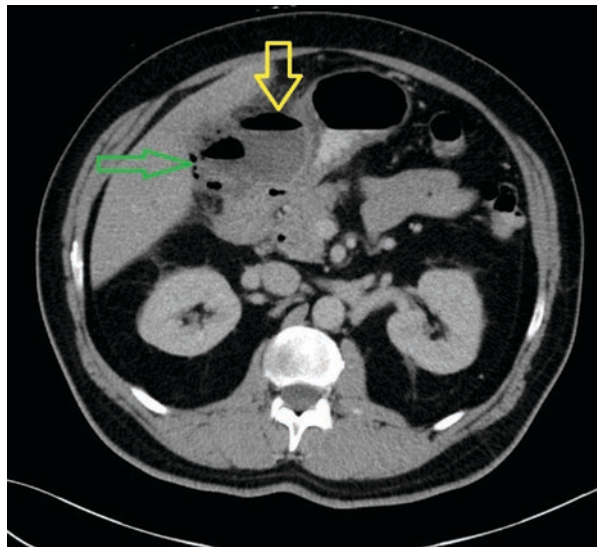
A 56-year-old lady presented with a 2 weeks history of right upper quadrant pain, anorexia, weight loss and night sweats. A provisional clinical diagnosis was made of a hepatic abscess. The CT demonstrated acute emphysematous cholecystitis (green arrow) associated with an abscess (yellow arrow) adjacent to the gallbladder due to a contained perforation
